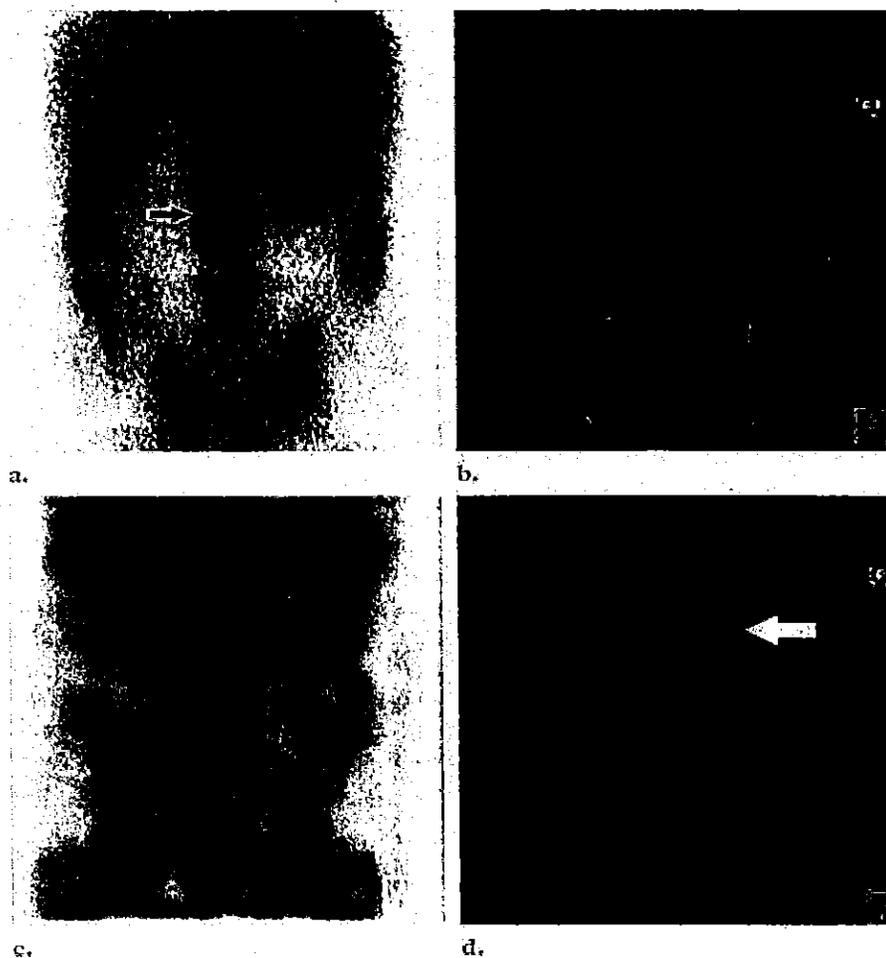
Localization of gallium uptake with SPECT/CT in a patient suspected to have a spine infection. (a) Planar image shows findings indicative of a spine infection (arrow). However, the location of the infection is not clear. (b–d) CT (b), SPECT (c), and fusion (d) images show clear correspondence between the abnormal scintigraphic findings and the defects seen at CT (arrow in d). The diagnosis of discitis with associated bone involvement was made by using both modalities.
